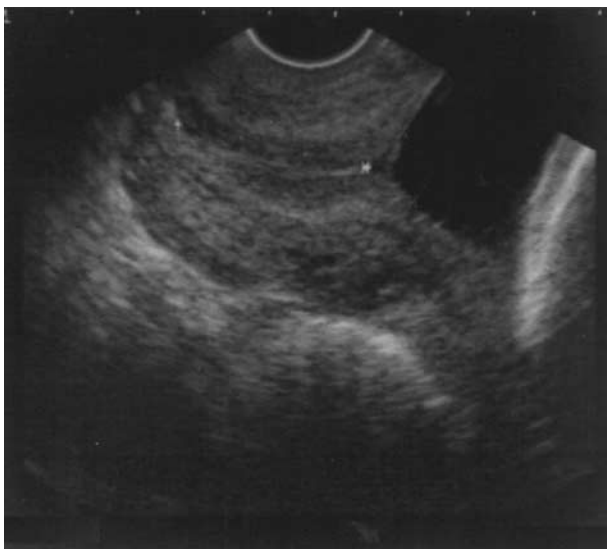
Transvaginal Ultrasound Image of a Normal Cervix. Calipers have been placed at the internal os (right) and the external os (left).
